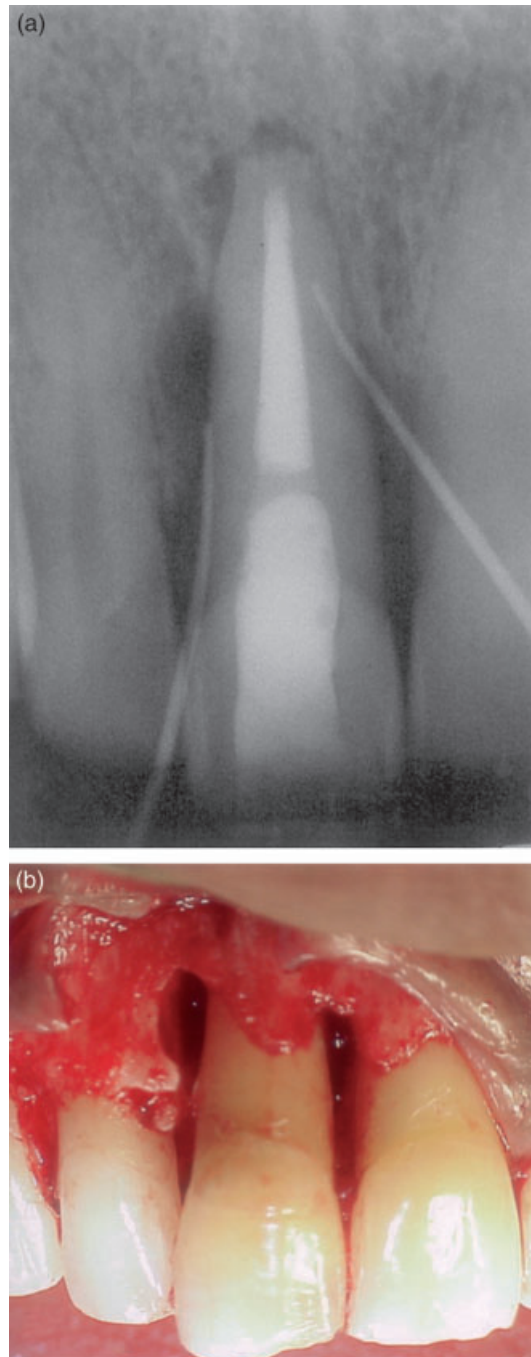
(a) Pre-operative radiograph with sinus tracts traced, (b) buccal flap reflected.
